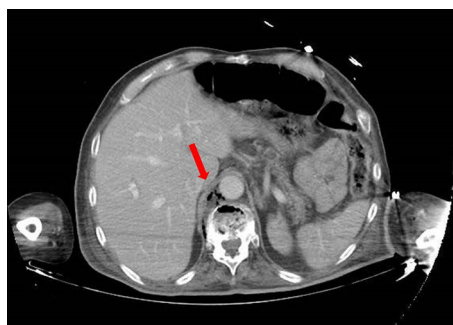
Axial CT scan of the abdomen.
